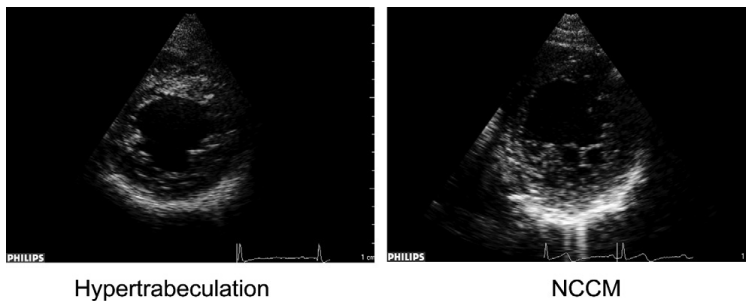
Example of echocardiographic short-axis images of both subjects with hypertrabeculation and noncompaction cardiomyopathy (NCCM) patients.
